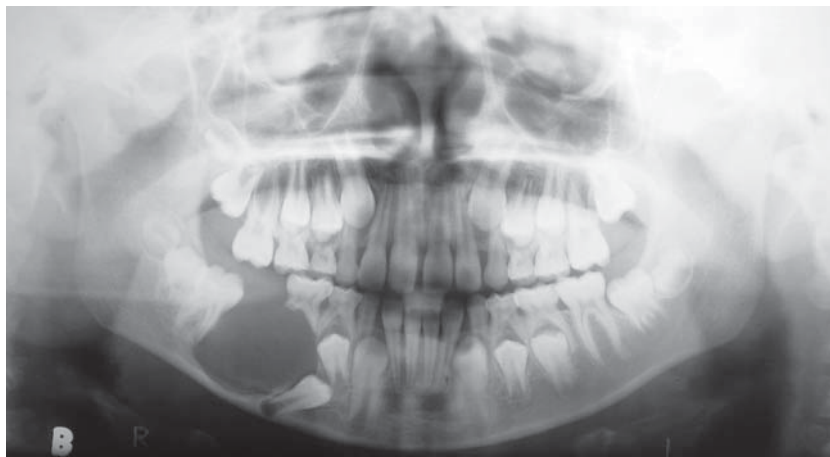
Panoramic radiograph showing initial aspect of tumor
